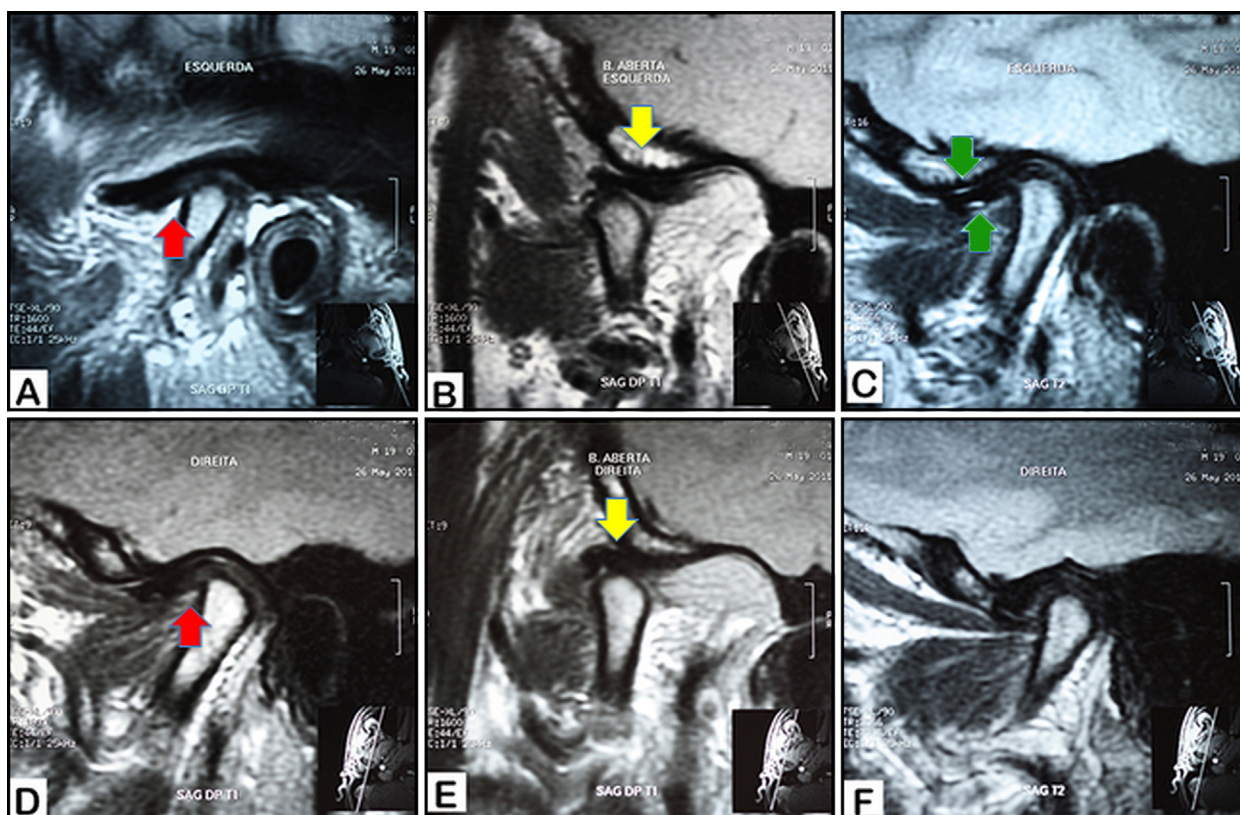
Pretreatment sagittal oblique TMJ: A-C, left and D-F, right fast spin echo MRI. T2-weighted closed-mouth position proton density shows left and right articular discs with normal morphology and slight anterior displacements with lack of contact between the condylar head and the intermediate zone (*red arrows in A and D*). Open-mouth positions depict adequate disc reduction (*yellow arrows in B and E*). Left T2-weighted closed-mouth position (*green arrows in C*) depicts line of hypersignal (level 1) on the upper and lower TMJ compartments. Right T2-weighted closed-mouth position depicts no intracapsular hyper signal (F).
